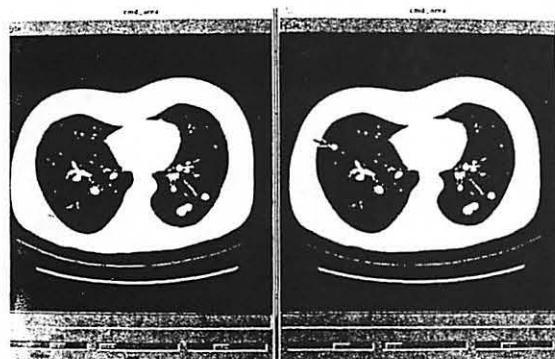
Left: a CT scan of the chest; right: the same scan with a digitally inserted tumor (see arrow). The insertion process requires minimal image processing (courtesy of Dr X. Zhu).
